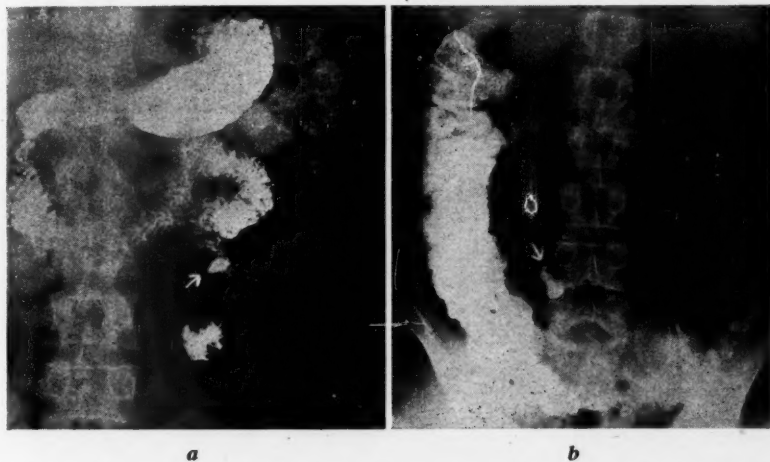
(a) Roentgenogram showing ulcerating lesion in upper jejunum. (b) Roentgenogram showing Meckel's diverticulum in distal ileum.
